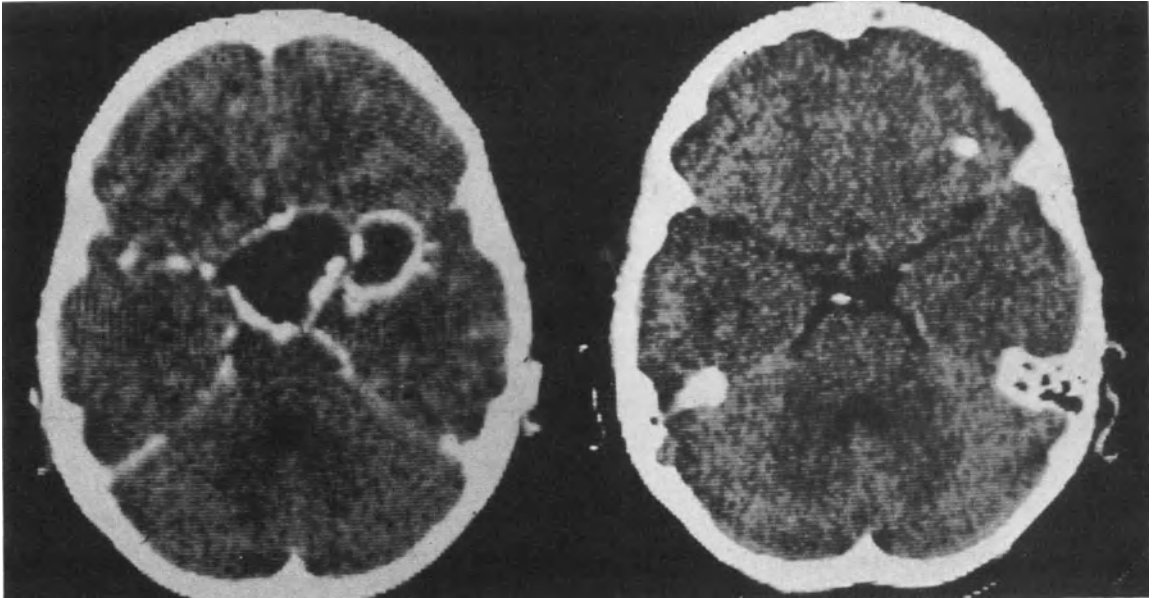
Axial CT section through a craniopharyngioma consisting of two communicating cysts. (This was a tumor that recurred two years after microsurgical removal in an eight-year-old boy.) Left: before therapy; right: five years after.
